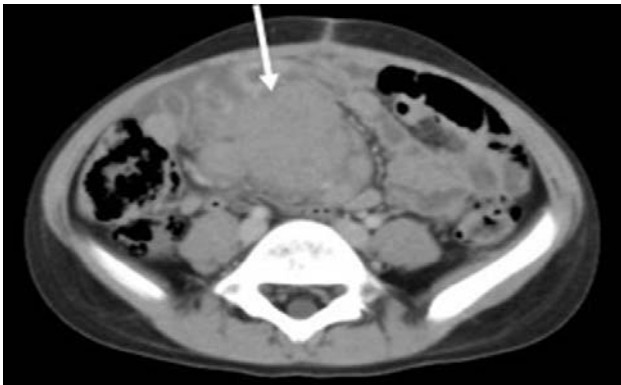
CT with contrast showing lobulated large mass in small bowel lymphoma mesentery
